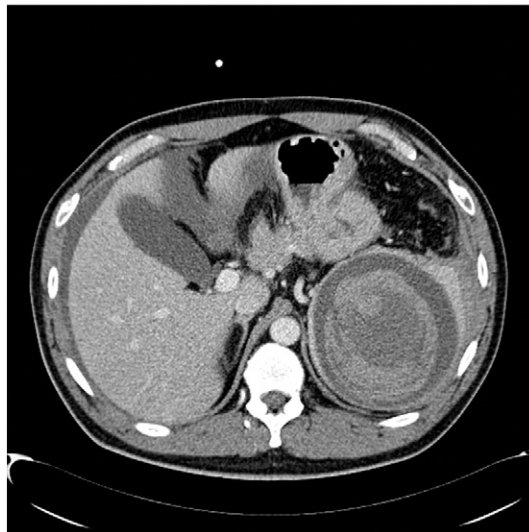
Abdominopelvic computed tomography scan reveals a large cystic mass originating from the spleen. Increased central intensity is noted that is indicative of active hemorrhage into a pre-existing splenic cyst or a large pseudoaneurysm.
